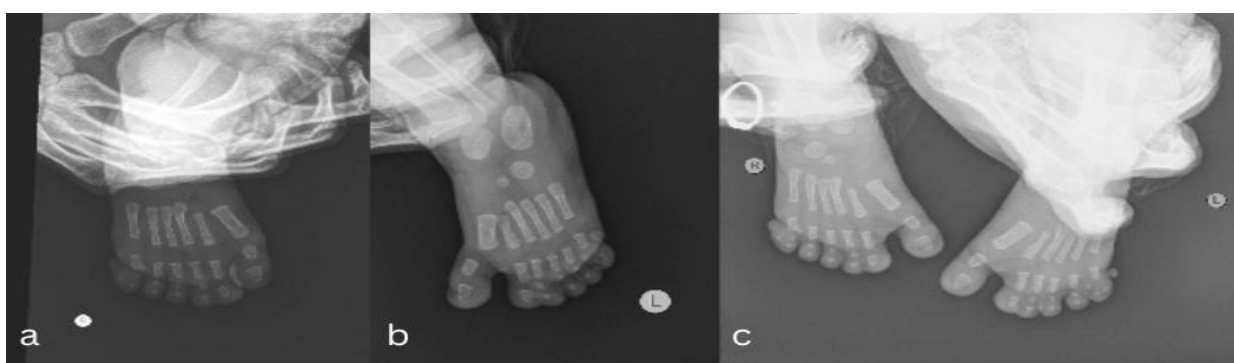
a. Right foot; b. Left foot; c. anteroposterior radiographic imaging of the feet
